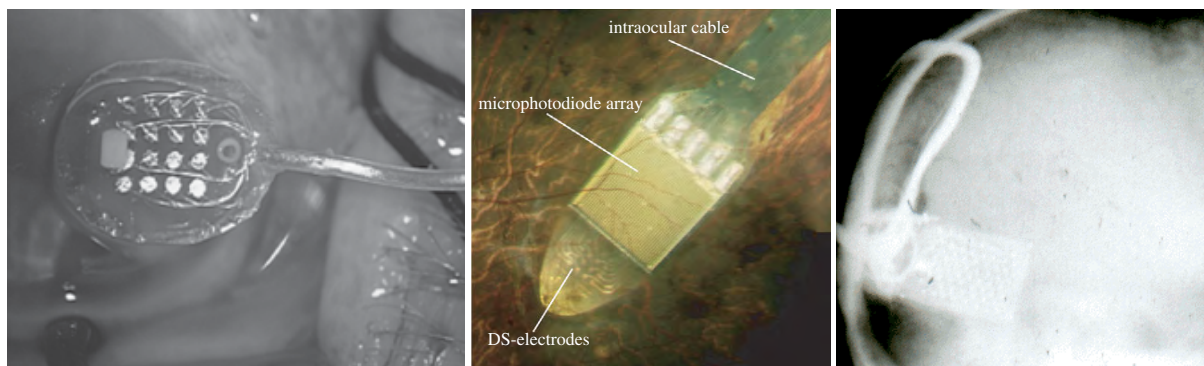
(*left*) Photograph of the Model 1 epiretinal microelectrode array (Second Sight Medical Products, Inc, Sylmar, CA) prior to insertion into the ocular vitreous cavity. (*center*) Retinal Implant AG (Reutlingen, Germany) subretinal combined photodiode/electrode array with 1500 sensors and electrodes. (*right*), X-ray of implanted cortical array (Dobelle, 2000) positioned on the occipital cortex.
